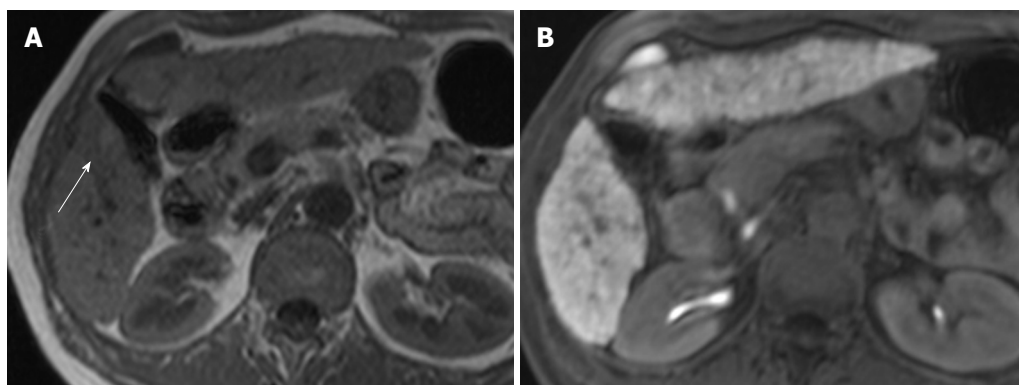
A 70-year-old woman with dysplastic nodule (arrow). A: The lesion shows hyperintensity on T1 weighted images; B: Isointensity in hepatobiliary phase on gadoxetic acid-enhanced magnetic resonance imaging.
